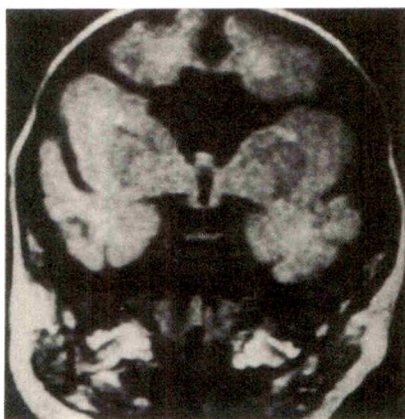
Coronal SE 600/20 MR image of patient with bilateral schizencephaly. Septum pellucidum is completely absent. Shape of frontal horns is distorted by clefts.
